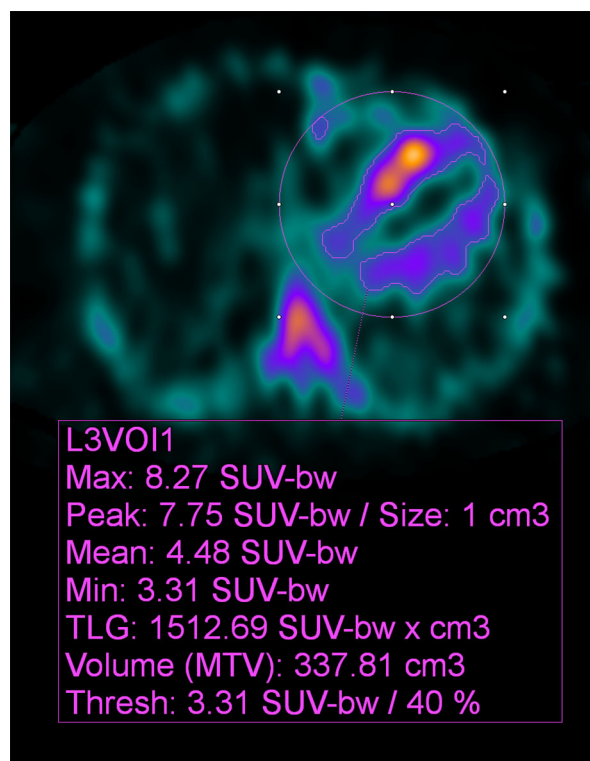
Transaxial quantitative SPECT image of the thorax showing sample measurements of myocardial uptake of HMDP (TLG total lesion glycolysis = cardiac metabolic activity, MTV metabolic tumor volume = cardiac metabolic volume).
